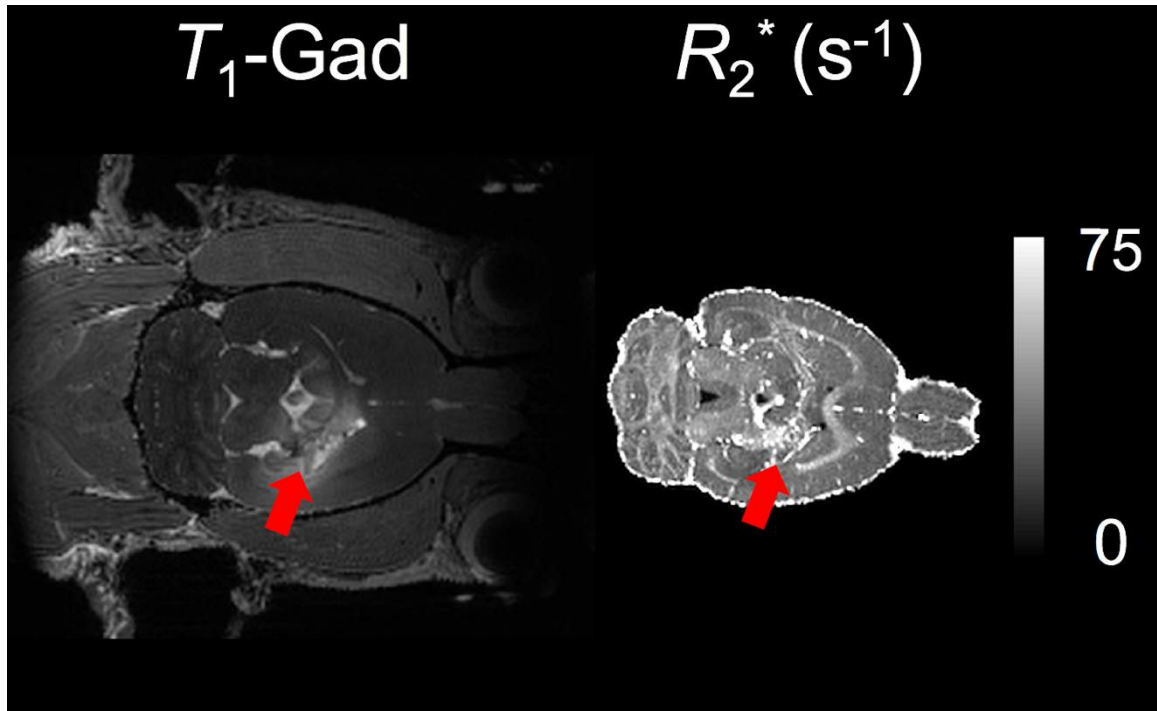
Radiation necrosis developed at the internal and external capsule, as shown by T_1 -gadolinium enhancing MRI (a) and increased R_2^* (b).
